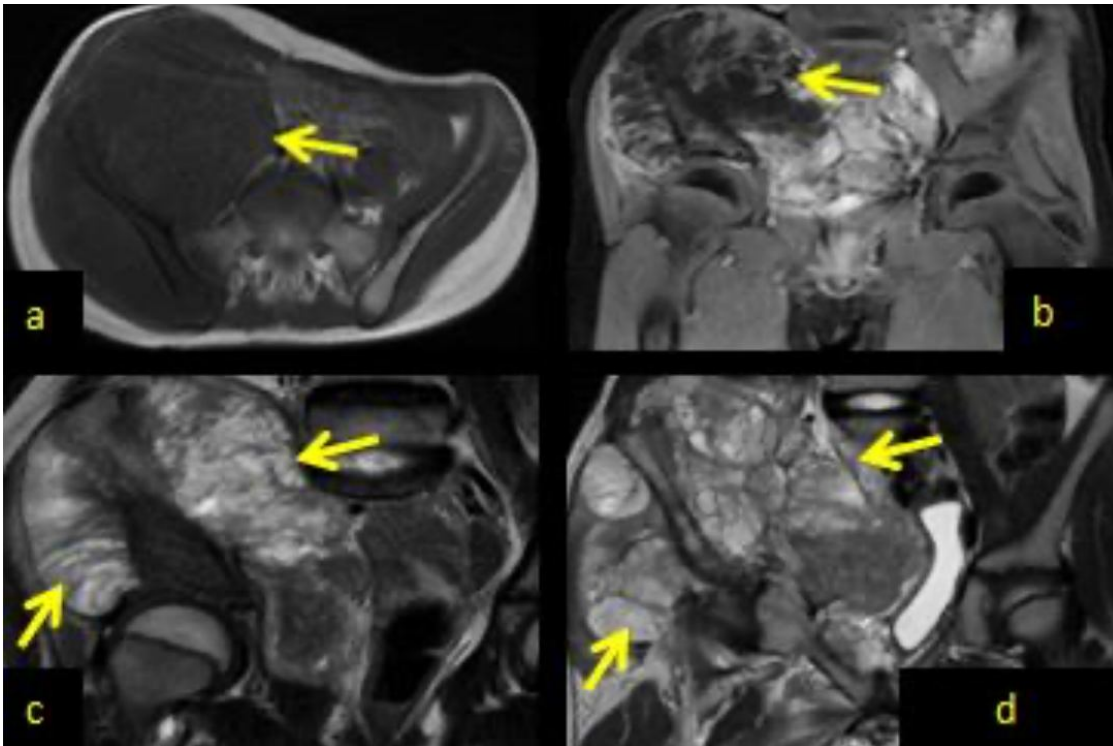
Pelvic MRI in axial T1-weighted sequence without (a) and after (b) gadolinium injection, and in sagittal section T2-weighted sequence before (c) and 5 months after surgical resection (d). The images show a tumor process centered on the right iliac wing, multi-localized, in hyposignal T1 (a), enhanced by Gadolinium (b). The tumor shows a heterogeneous T2 hypersignal, with multiple thick septa in T2 hyposignal (c). There is a compact periosteal reaction opposite, without invasion of adjacent organs.
